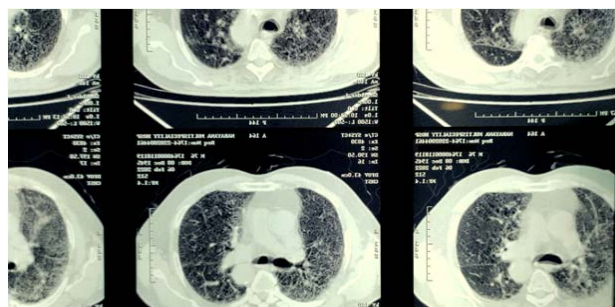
HRCT scan of thorax of Case 1 showing bilateral ground glass opacities
